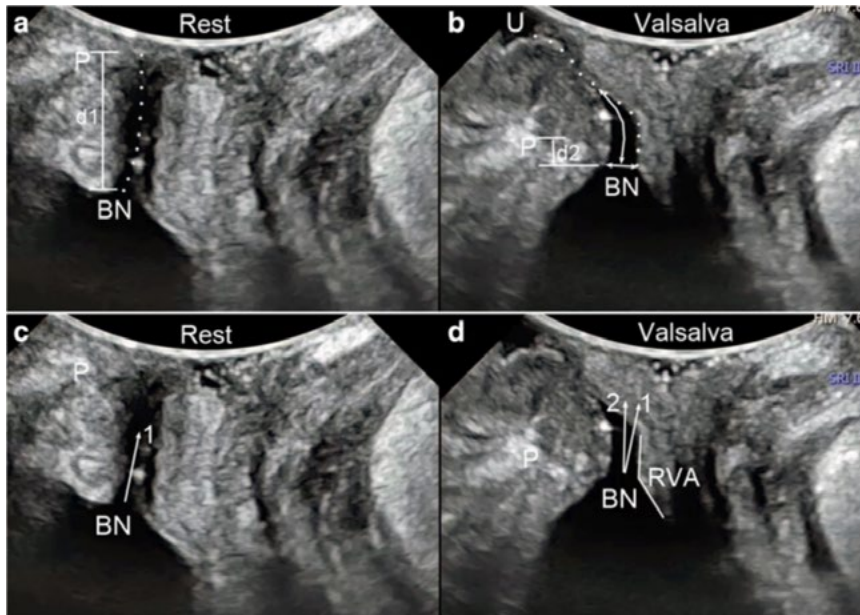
Transperineal ultrasound images in the mid-sagittal plane during real-time leaking. A and C were taken at rest, B and D during the Valsalva manoeuvre. A and b Urethral movement during the Valsalva manoeuvre; the dotted line in A shows the urethra at rest while in B it shows the urethra during the Valsalva manoeuvre. The length of the dotted line is equal to the urethral length. B Funnelling measurements (the long arrow shows the funnelling length and the short arrow shows the funnelling width) and urine leakage, seen as fluid (urine) between the external urethral orifice and the probe surface. A and b Measurement of the position of the bladder neck relative to the posterior inferior margin of the pubic symphysis (P); the difference between these measurements during the peak of the Valsalva manoeuvre and at rest ($d1-d2$) produces the value for bladder neck descent (BND). C and d Measurement of the urethral rotation angle (URA), which is the angle between the proximal urethra at rest (arrow 1) and during the Valsalva manoeuvre (arrow 2). D The retrovesical angle (RVA) during the Valsalva manoeuvre, which is measured between the proximal urethra and the trigone. P: symphysis pubis, BN: bladder neck, URA: urethral rotation angle, RVA: retrovesical angle, U: urine. (140)
